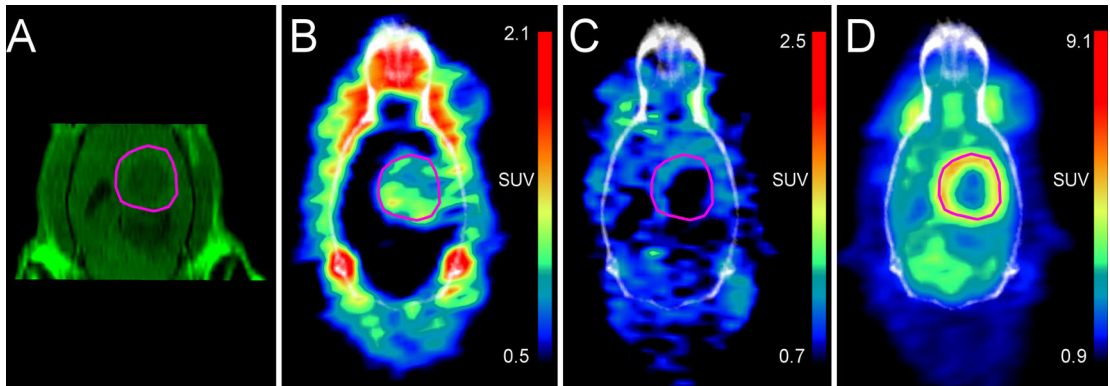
Array of *in vivo* images acquired on four consecutive days of a single BDIX subject bearing a BT4C glioma (outlined in magenta) with tri-cubic visual interpolation. A contrast enhanced T1 MRI image used to delineate tumour boundaries. B $[^{18}\text{F}]\text{FGIn}$ PET/CT, 15.8 MBq injection, time-weighted mean frames from 15-60 minutes. C $[^{11}\text{C}]\text{Met}$ PET/CT, 50.4 MBq injection, time-weighted mean frames from 9-20 minutes. D $[^{18}\text{F}]\text{FDG}$ PET/CT, 24.0 MBq injection, time-weighted mean frames from 35-60 minutes.
